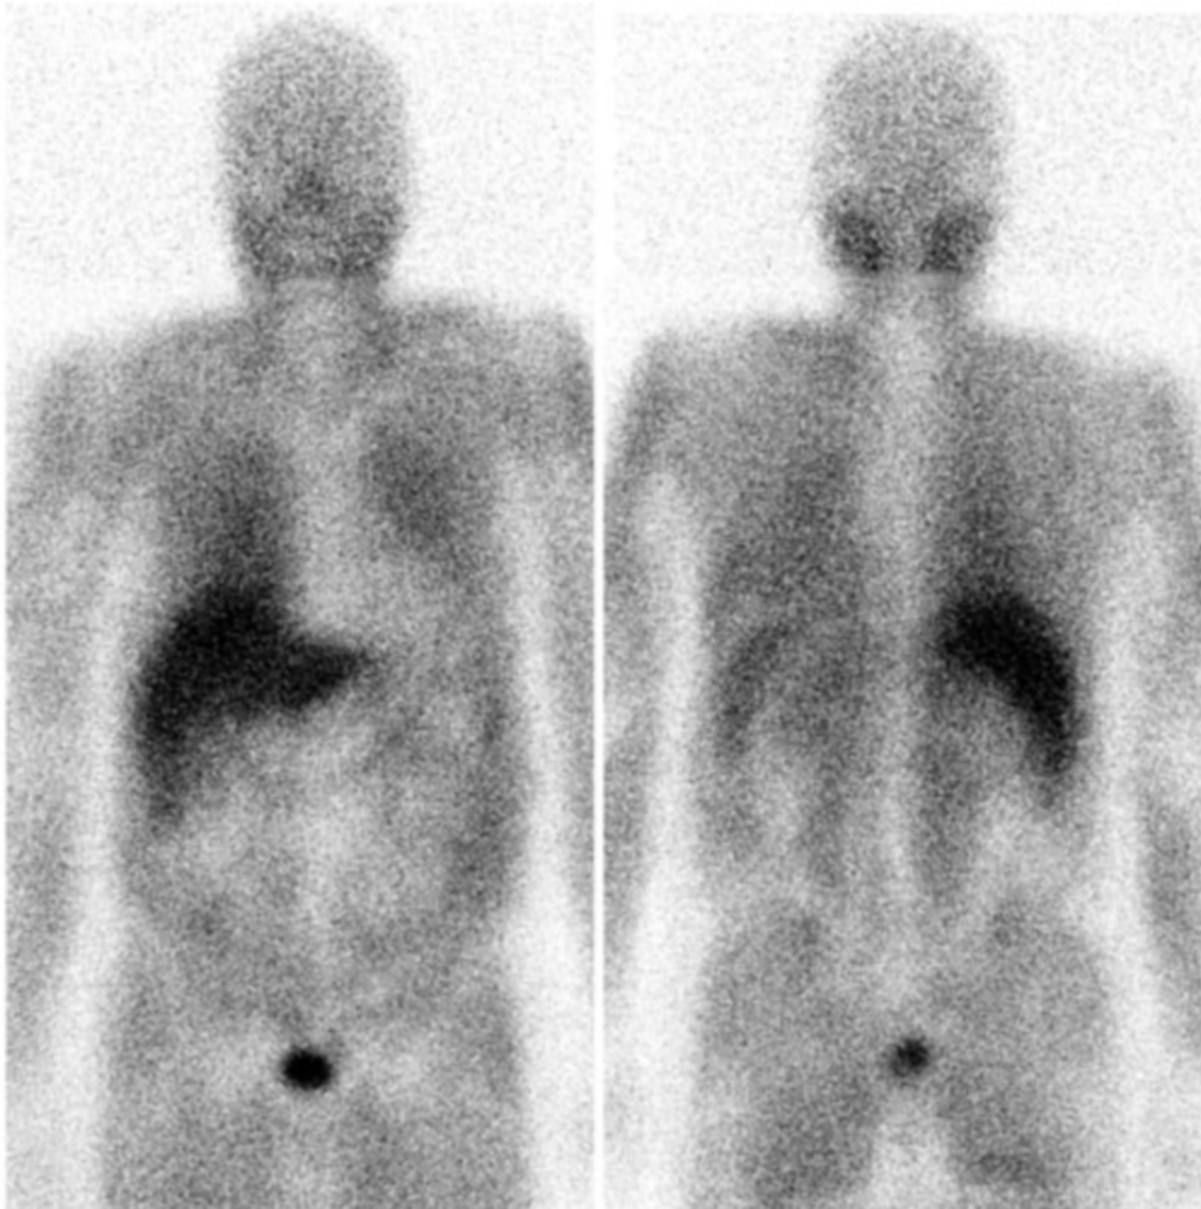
61-year-old man with suspected pheochromocytoma. Anterior and posterior I-123-MIBG scintigraphy at 24 hours demonstrates abnormal diffuse uptake of tracer throughout the muscles. No focal areas of MIBG uptake that would suggest pheochromocytoma are identified.
